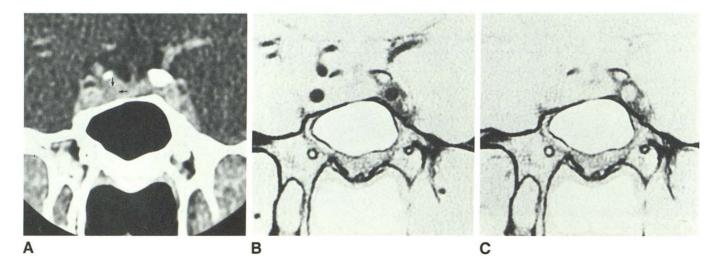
Amenorrhea-galactorrhea and hyperprolactinemia in 48-year-old woman treated with bromocriptine for 3 years (case 4). A, Conventional coronal CT scan shows poorly delineated left adenoma (arrows).
